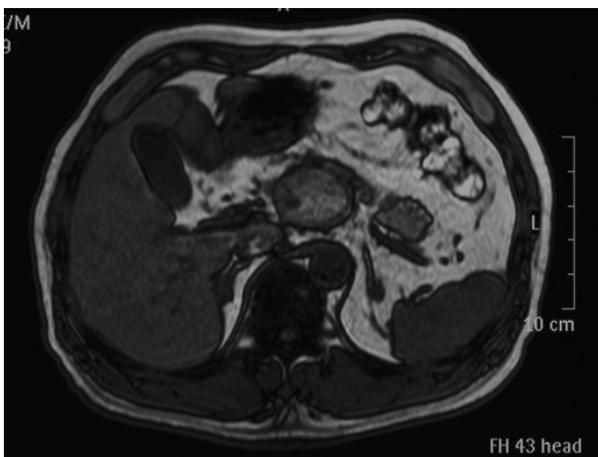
Axial T1-weighted magnetic resonance image of the abdomen showed a well-circumscribed cystic lesion, 5.0x4.5x4.0 cm in size. The content showed high signal intensity on T1-weighted image.
